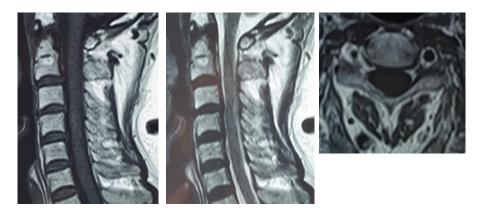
The second MRI showed that the hematoma at the C2-C4 level was almost entirely absorbed ten days afterward. Only thin layer of blood clot was withnessed on these images (arrow).
